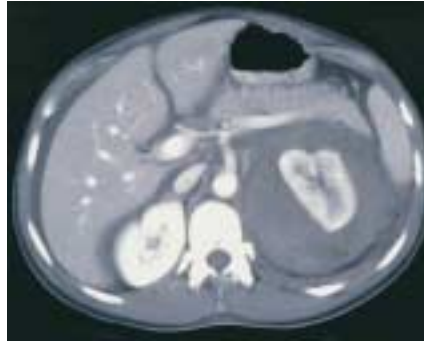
CT scan, obtained the day after admission because the patient's abdomen became distended, revealed a large left perinephric hematoma.
